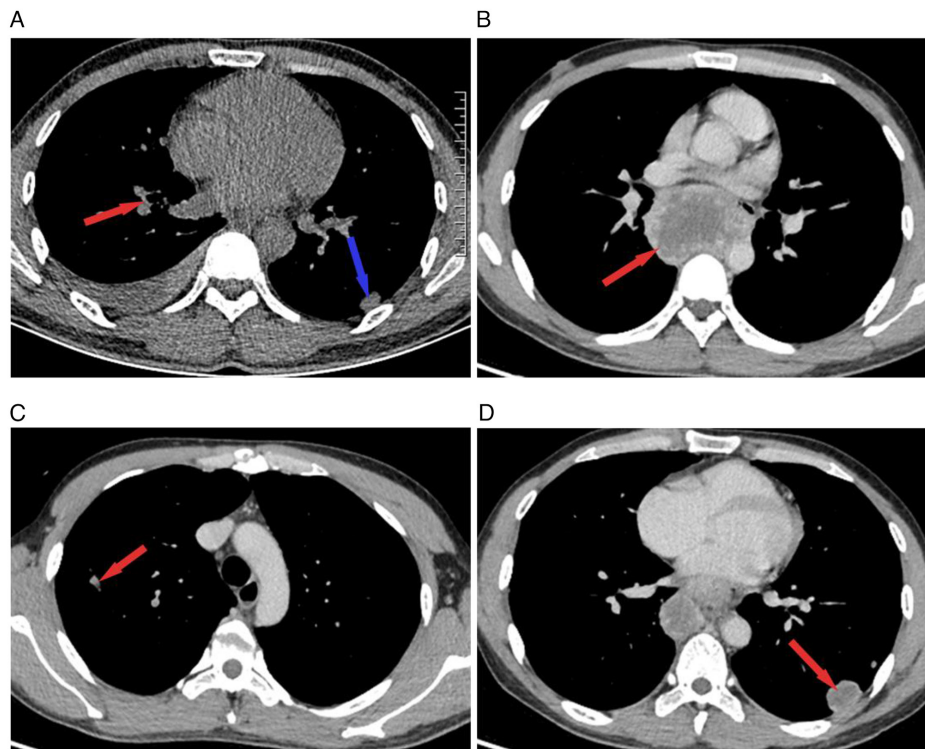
The changes of chest CT during September on mediastinal window. (A) Chest CT scan showing a 1.6x0.8-cm nodule in the right upper lobe (red arrow) and a 1.9x1.2-cm nodule in the left inferior lobe (blue arrow), with pleural effusion in the right lung. (B) Chest CT indicating an edge enhancement obvious and huge mass ~6.5x5.1x6.9-cm in the posterior mediastinal. (C and D) Chest CT showing multiple nodules of varying sizes in the upper and lower lobes of both lungs and the larger ones measuring ~2.5x1.8-cm in the lower lobe of the left lung. The pleural effusion disappeared. CT, computed tomography.
